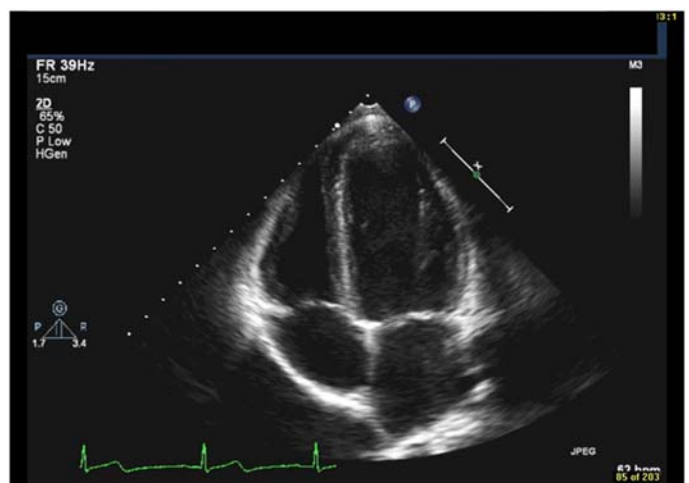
Apical four chamber view (AP4CH)
